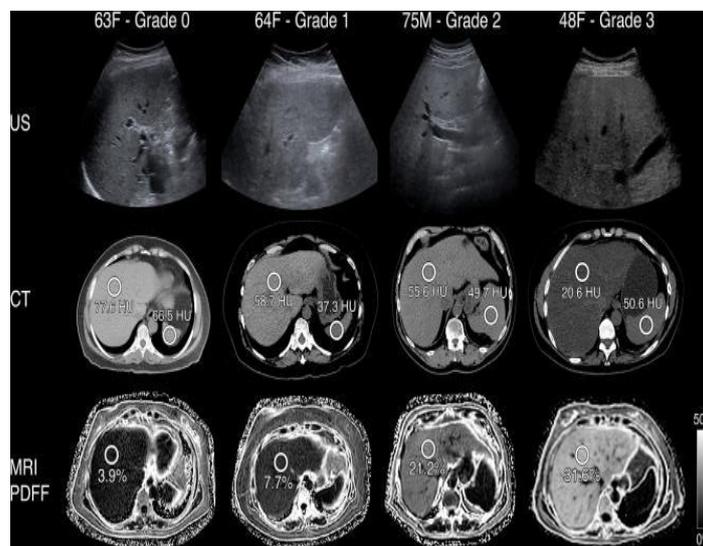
shows MRI, CT, and ultrasound images of hepatic steatosis. Images from MRI-PDFF (row 3), CT (row 2), and ultrasound (row 1) are displayed for steatosis grades 0 (none) to 3 (severe). Unenhanced CT reveals decreasing liver attenuation (darker parenchyma) while spleen attenuation stays greater; MRI PDFF values rise (showing more fat); and ultrasound indicates gradually increased liver echogenicity and blurring of arteries as the steatosis grade increases from left to right. These show how the fat burden is reflected in each modality.
